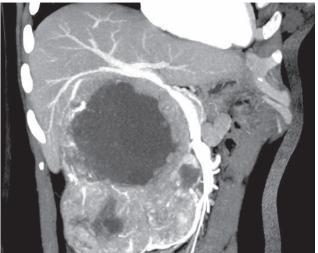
Preoperative contrast-enhanced CT. (a) Multiloculated intra-abdominal mass with enhancing septa, measuring $12 \times 14 \times 19$ cm with mild dilatation of the main pancreatic duct, and (b) mass effect to main portal vein, hepatic artery, and biliary ducts.
